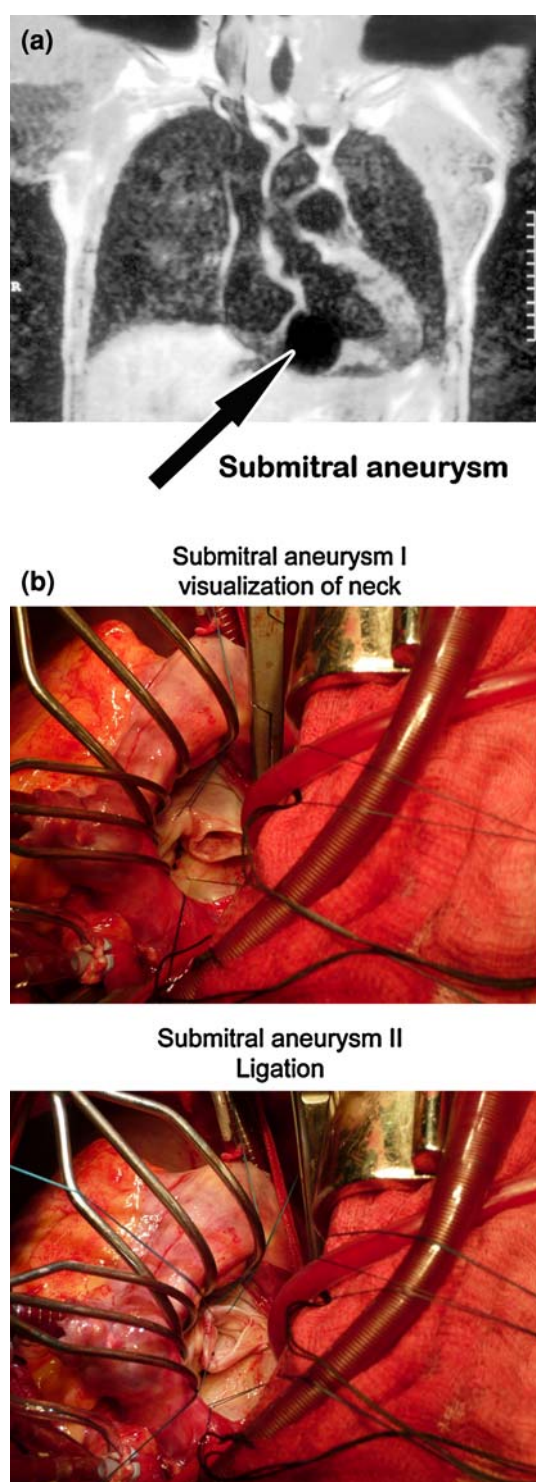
a Submitral aneurysm (MRI). b Intra-operative photograph of a submitral aneurysm from epicardial surface. The neck was closed on interrupted sutures and the valve repaired with a complete ring
